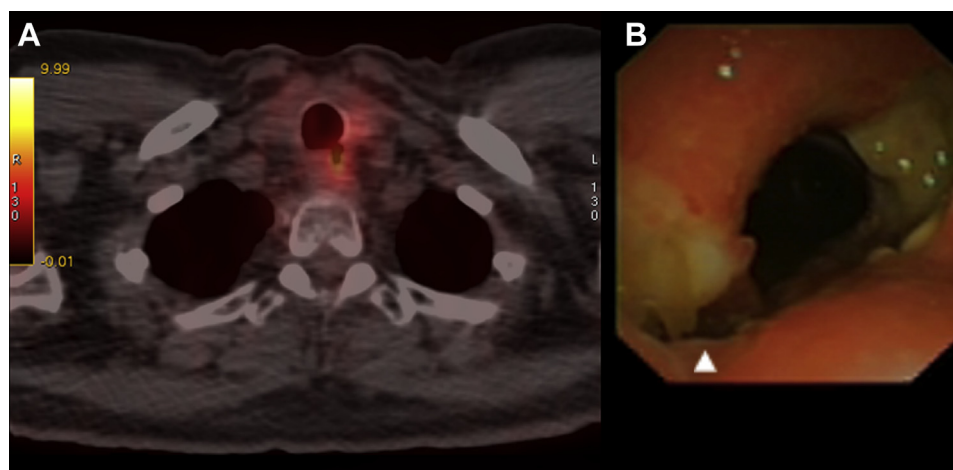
A, PET-CT scan of the chest showing a diverticulum nearly fistulizing into the mediastinum in the left posterior wall of the upper trachea with slightly increased metabolic activity. B, Tracheal view showing a left posterior wall diverticulum (white arrowhead) and a right anterolateral wall tracheal ulceration covered by purulent secretions before treatment.
